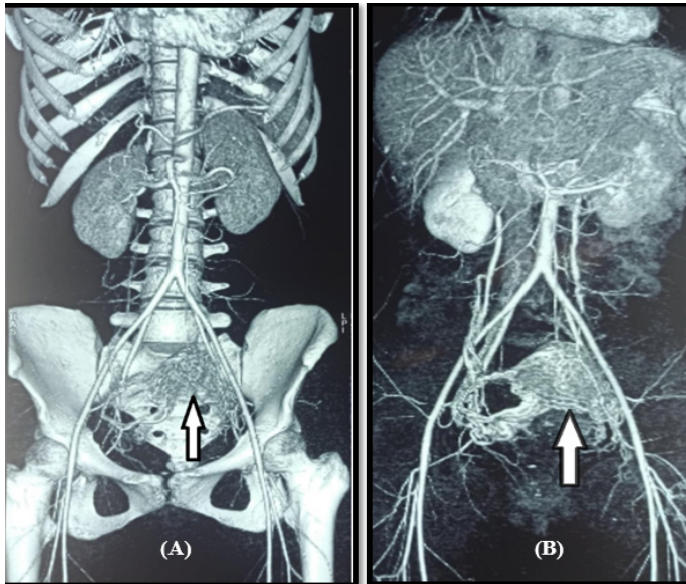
Showing CT angiogram of the patient (A) Early arterial phase (B) Delayed phase
